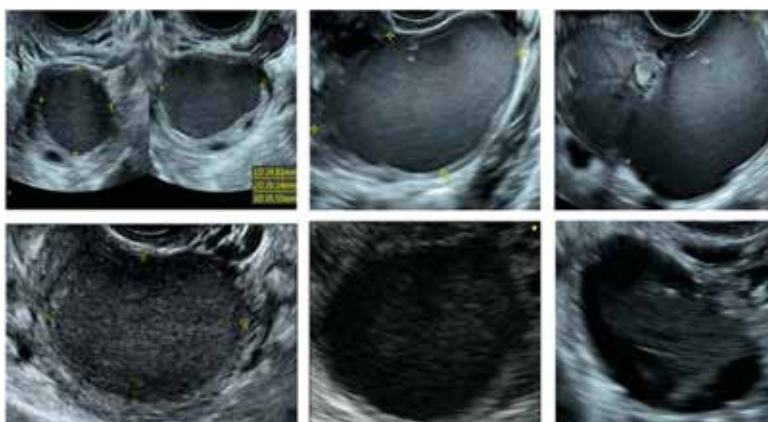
Grayscale images of typical ultrasonographic endometriomas: unilocular cysts with a ground-glass appearance inside the ovary.<sup>25</sup>
